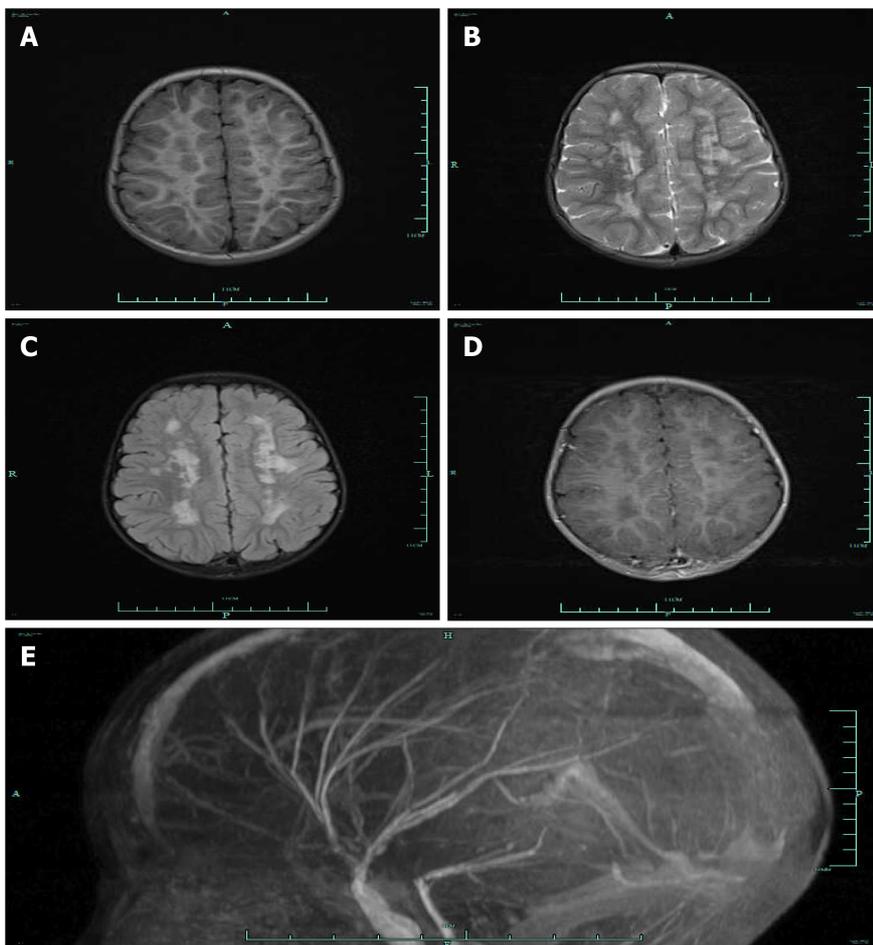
Cerebral magnetic resonance imaging (axial T1-weighted, T2-weighted, fluid attenuated inversion recovery images) for the patient with multi-systemic smooth muscle dysfunction syndrome multiple. A-C: Cerebral Magnetic resonance imaging showed multiple aberrant signal shadows in bilateral paraventricular; D: There was no enhancement in contrast-enhanced scan; E: Lateral projection of magnetic resonance angiography indicated abnormally straight course of intracranial arteries.
